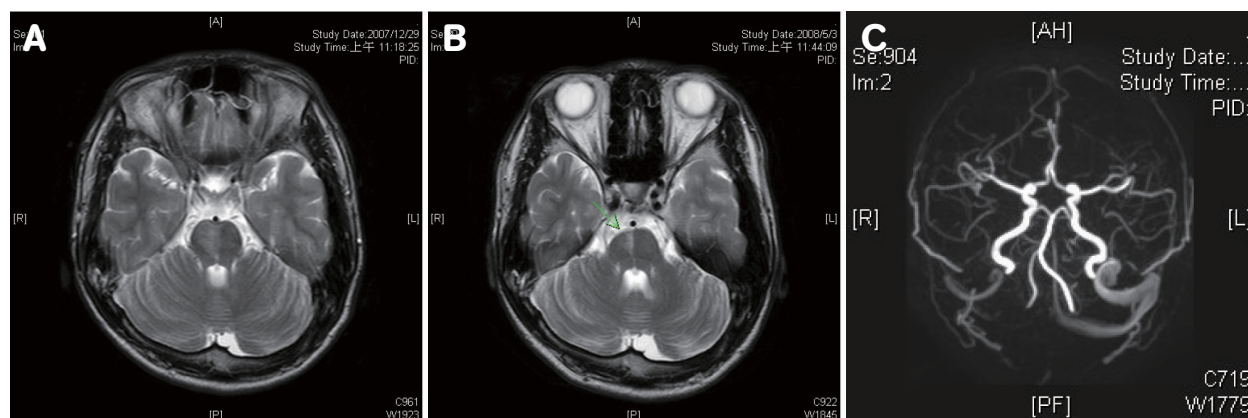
The follow-up axial T2-weighted image during administration reveals edema in the right pons. (A) The 5-month follow-up axial T2-weighted image reveals tissue loss and focal encephalomalacia (arrow) in the right pons. (B) A 5-month follow-up TOF (Time-of-Flight) MR angiogram demonstrates the normal appearance of the basilar artery and its distal branches. (C)
